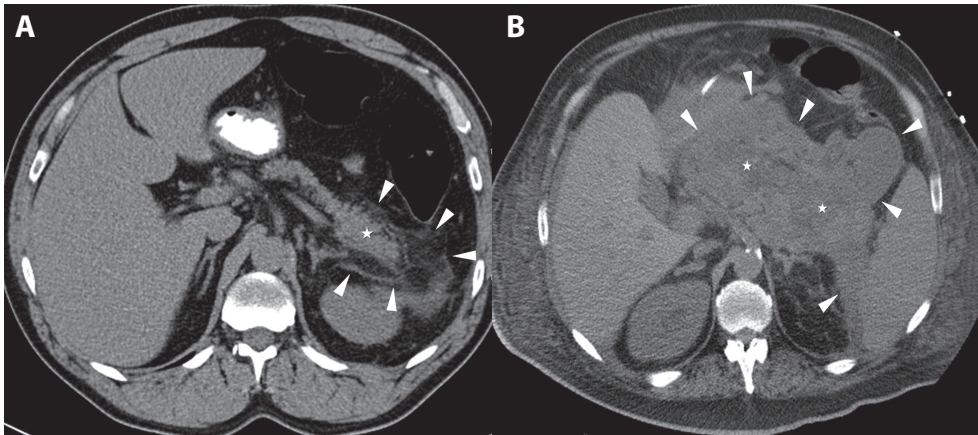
(A) A 35-year-old man with acute pancreatitis (Balthazar Grade C). Unenhanced CT shows a swollen pancreatic tail (white star) with peripancreatic fat stranding (arrowheads). (B) A 56-year-old man with acute pancreatitis (Balthazar Grade E). Unenhanced CT shows a heterogeneous pancreas (white stars) surrounded by multiple peripancreatic collections (arrowheads)
